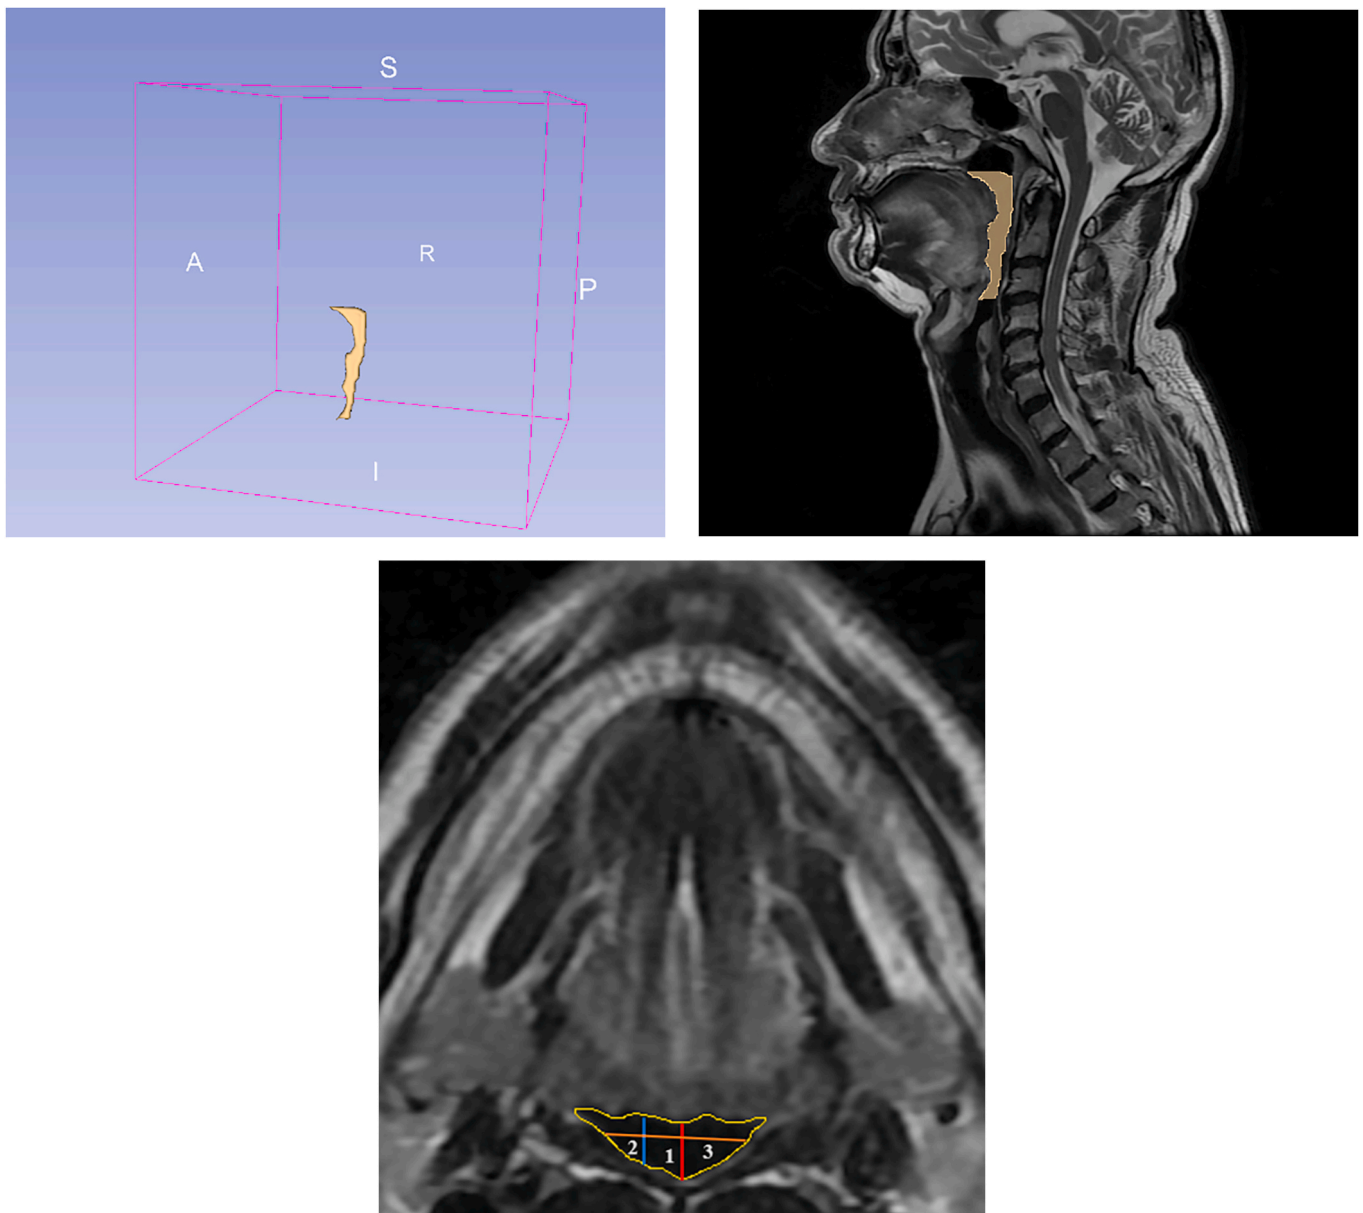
MRI image shows borders of the 3D volumes by presenting a pharyngeal airway segmentation for volumetric analysis. Fig. 2c shows A view of a measurement plane from the axis. The midsagittal plane is represented by the red line. The yellow line delineates the airway space. 1 = measurement along the midsagittal plane (Red). 2 = Represents a measurement of length taken in a cross-sectional plane (Blue). 3 = The measurement of the width in a cross-sectional view (Orange).
